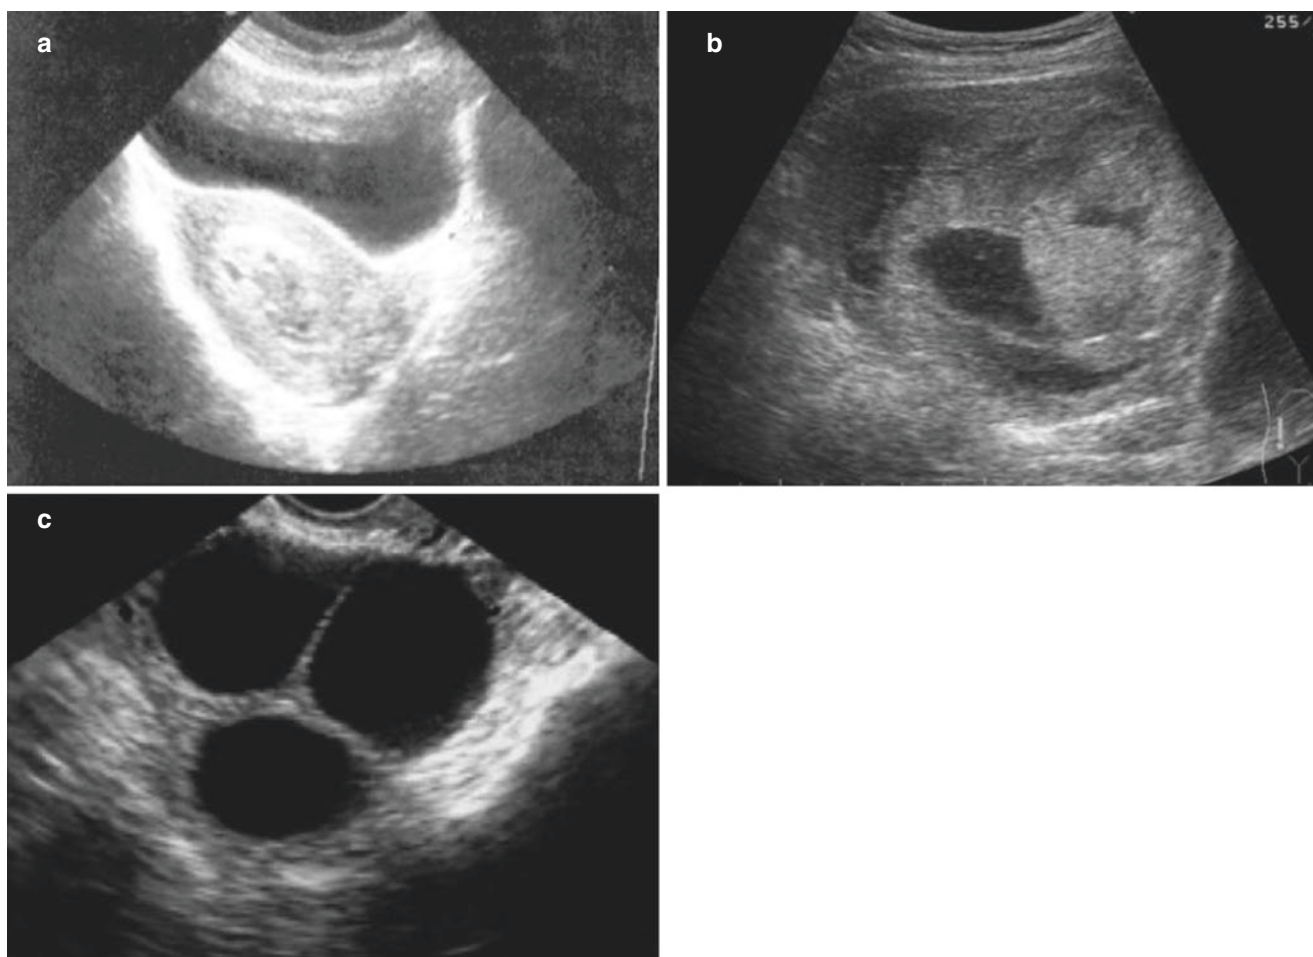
Hydatidiform mole (II). (a). After 13 weeks of amenorrhea, no normal fetus and placenta in the uterus. Heterogeneous hyperechoic mass is found in the uterine cavity, which is suspected of missed abortion by ultrasound, and it is pathologically diagnosed as hydatidiform
